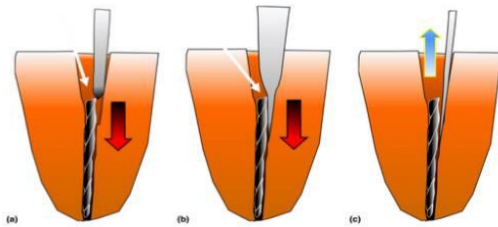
Size and taper of ultrasonic tips affecting instrument retrieval. (a) Large diameter/greater taper tip pushes the fractured instrument in an apical direction before being placed in the space. (b) Progressive taper pushes the fractured instrument in an apical direction as it is placed deeper in the space. (c) Small diameter/smaller taper tip placed in the space extrudes the fractured instrument in a coronal direction
